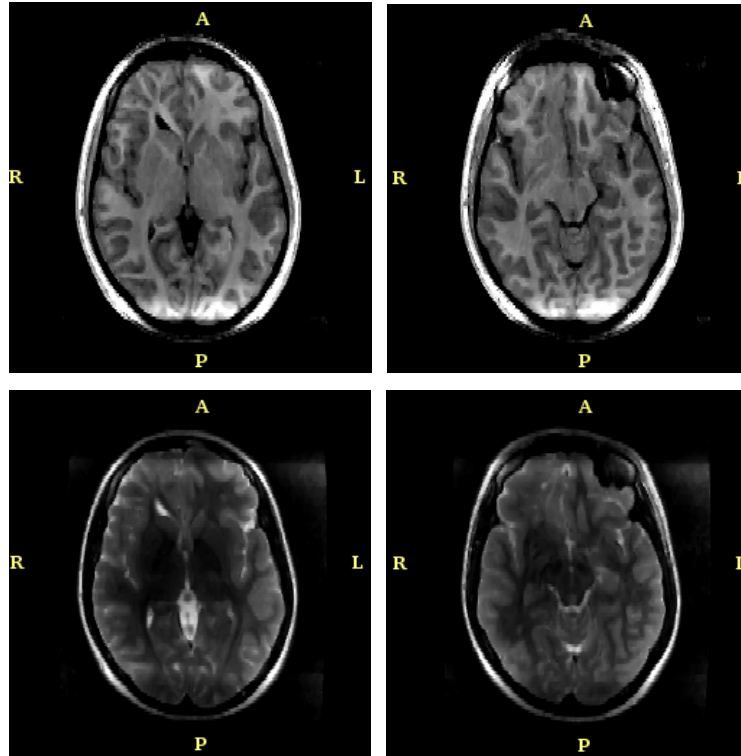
Patient Example 1 - Anisotropic Smoothing. Top Row: Edge-preserving Smoothed T1-weighted volume. Bottom Row: Edge-preserving Smoothed T2-weighted volume.
